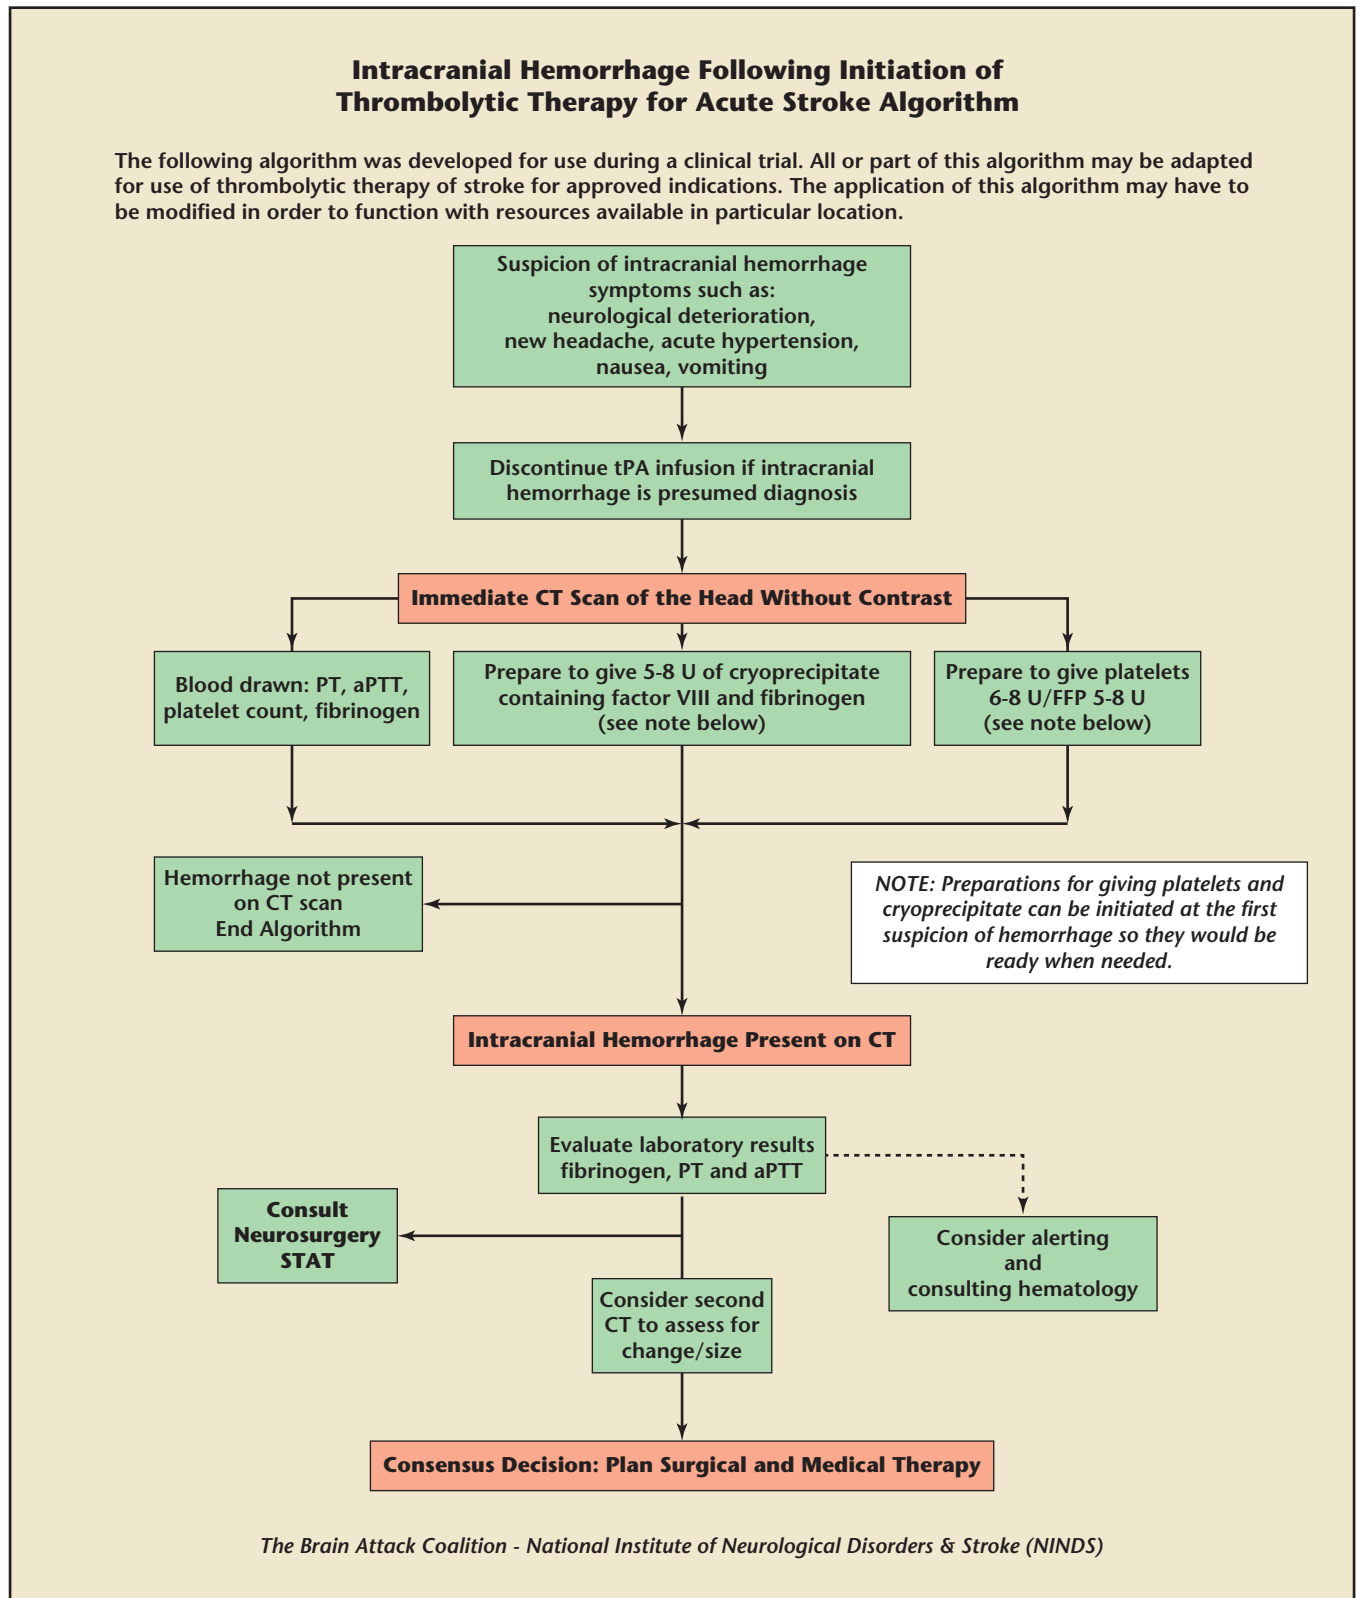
Order set for intracranial hemorrhage following initiation of thrombolytic therapy. aPTT, activated partial thromboplastin time; CBC, complete blood count; CT, computed tomography; INR, international normalized ratio; PT, prothrombin time; STAT, immediately; tPA, tissue plasminogen activator.
